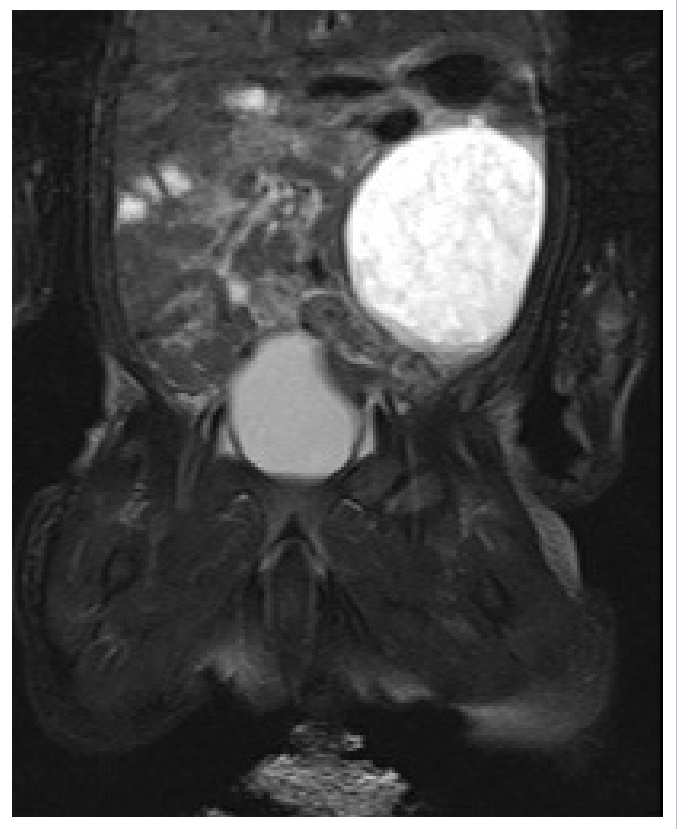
Magnetic resonance image of the mass.
